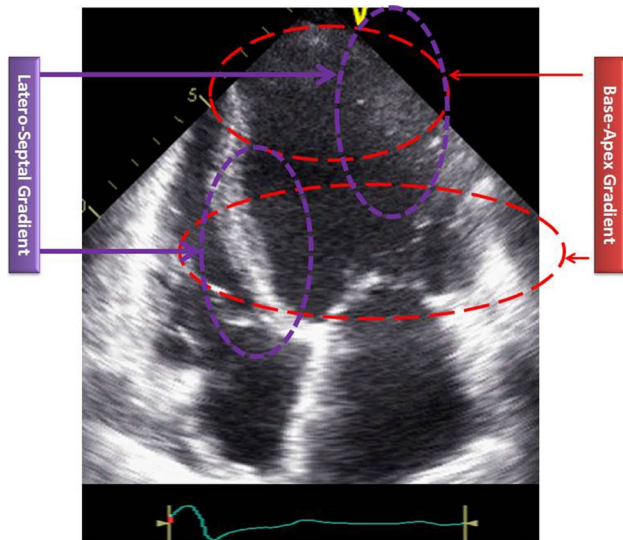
Example of an apical 4-chamber view of a DCM with the definition of latero-septal segments and basal–apical ones that were used for defining the gradients
